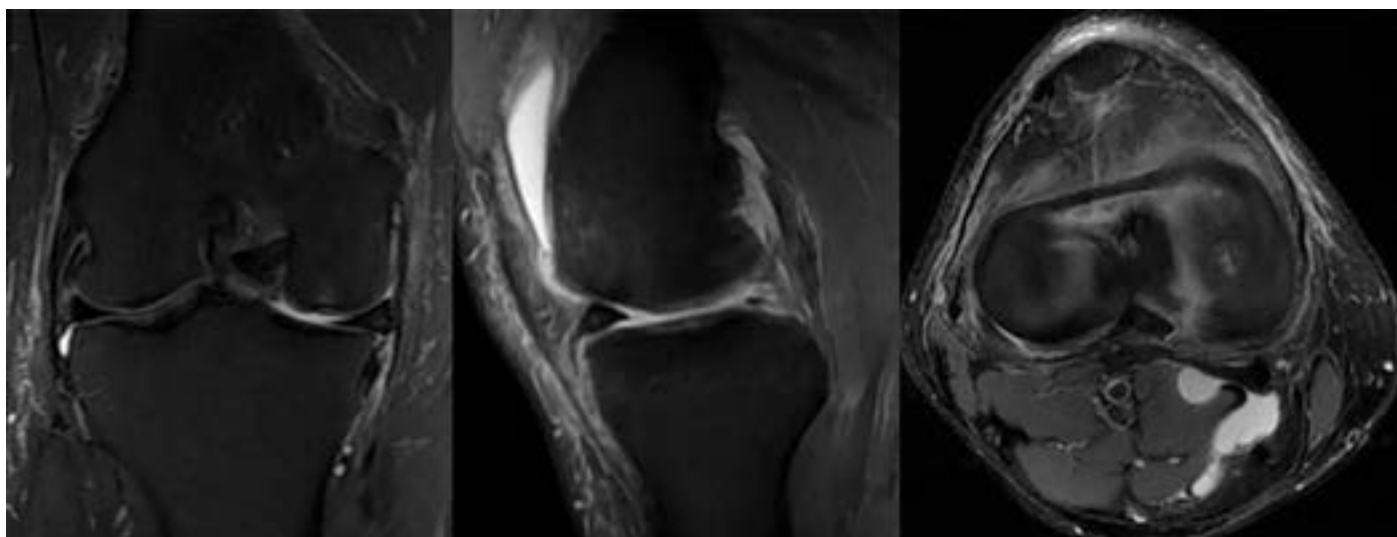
A coronal T2-weighted MRI section of a 50 year old female patient with a degenerative medial meniscus posterior root tear (Optima MR450 GE, Matrix 512\*512)
